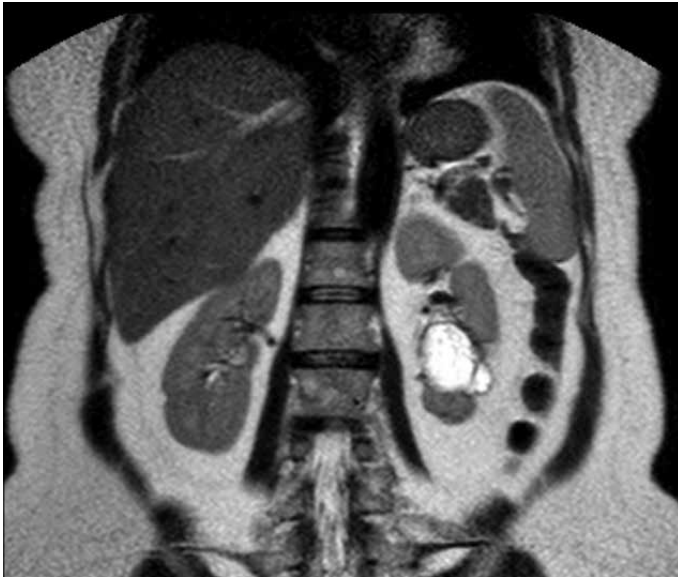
The thick-walled cystic lesion localized in the lower pole of the left kidney in magnetic resonance imaging
